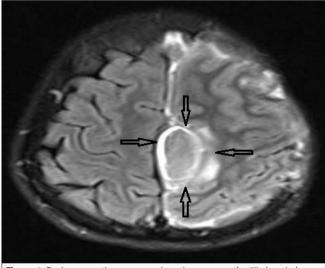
Brain magnetic resonance imaging scan on the 5th day. Lobulated and peripheral contrast enhancement brain abscesses in the interhemispheric area (black arrows)
